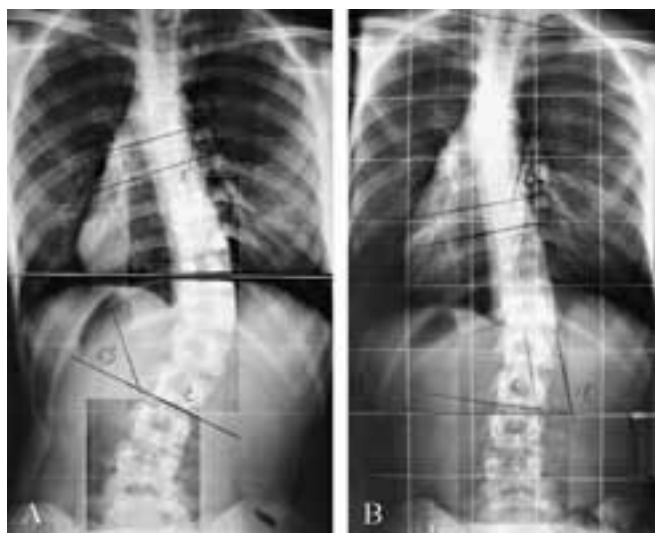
One of the best results obtained to date with the Sforzesco Brace. Silvia S., girl, born August 1988, menarche December 2000, Sforzesco brace treatment 23 h per day, with SEAS-02 exercises. Pretreatment (A) and short-term results after 6 months (radiograph without the brace) are shown (B). Clinical and radiographic data of this patient are reported in Table VIII.
